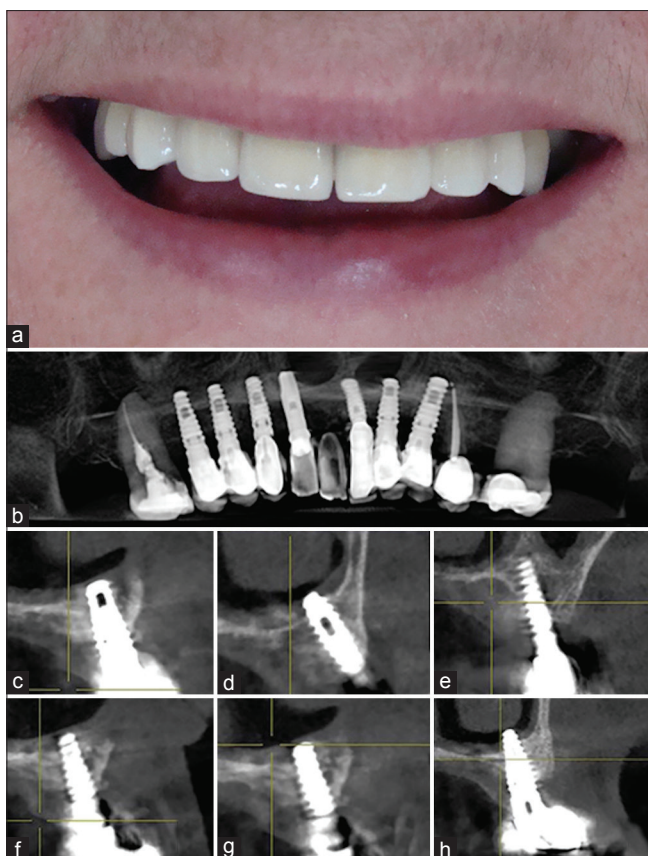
Clinical (a) and radiographic (b) aspect after the installation of implant-supported dental prostheses. Dental implants (c) 11, (d) 12, (e) 13, (f) 21, (g) 22, (h) 23
